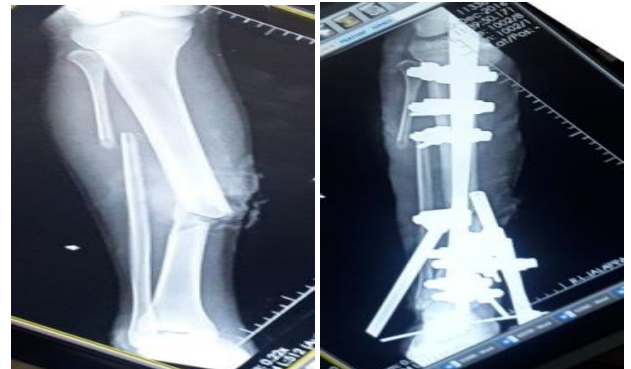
Fig x 13: Preop x-ray AP view immediate postop X-ray AP view
